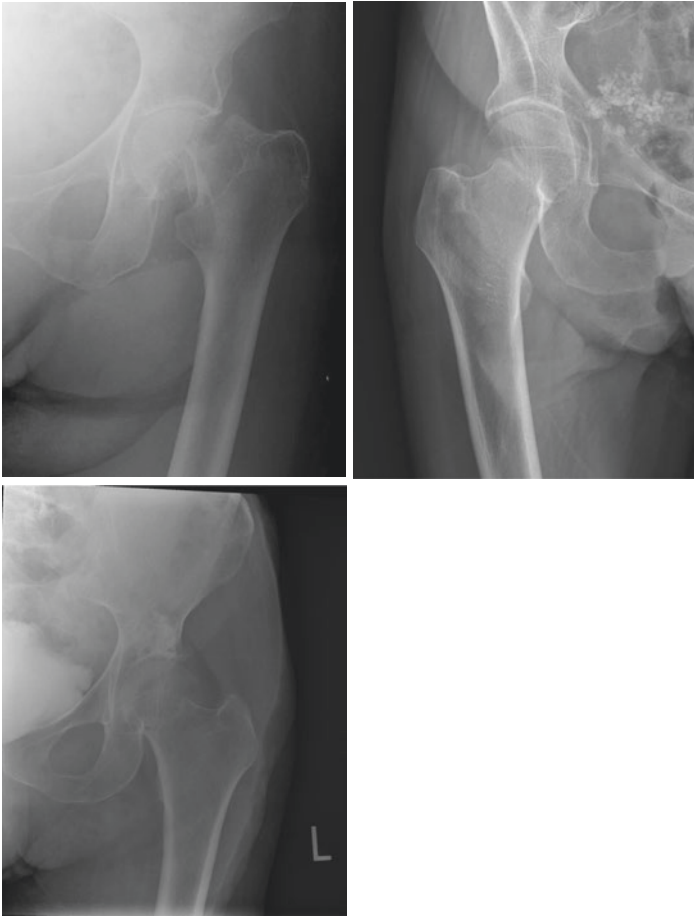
Representative radiographic images of femoral neck fractures
